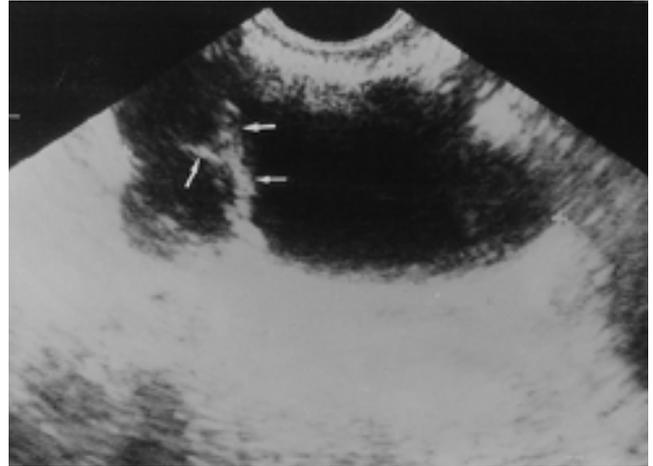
A 57-year-old female with a cystic fibrothecoma. Endovaginal sonogram reveals a multilocular cyst with multiple thick septa (arrows) in right adnexal region.
